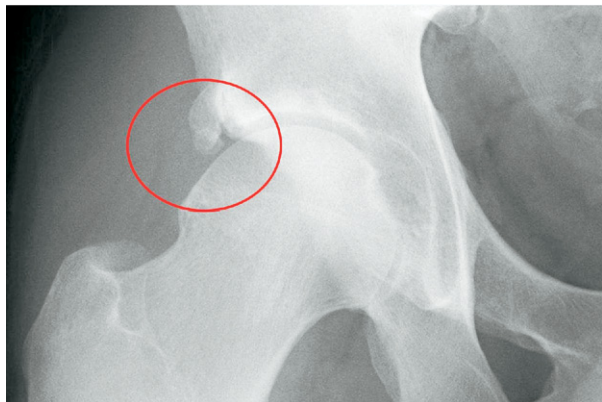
Radiographic evidence of an acetabular rim fracture.
